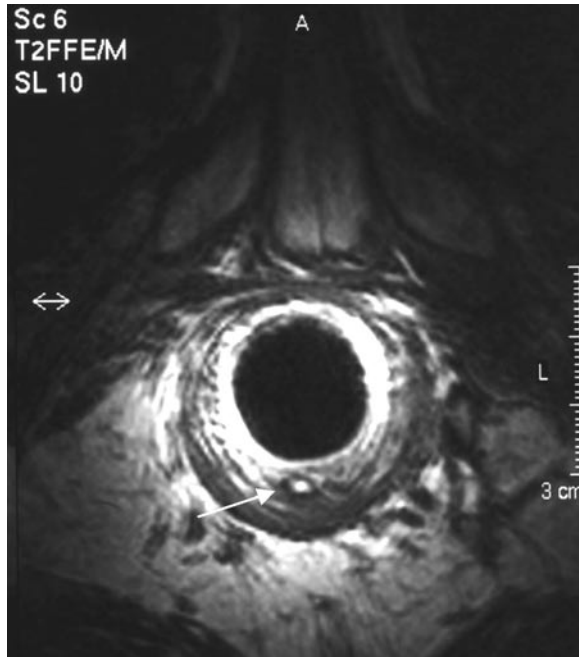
Axial T2-weighted turbo spin-echo with endoanal coil reveals an intersphincteric track in the posterior midline (*arrows*)
